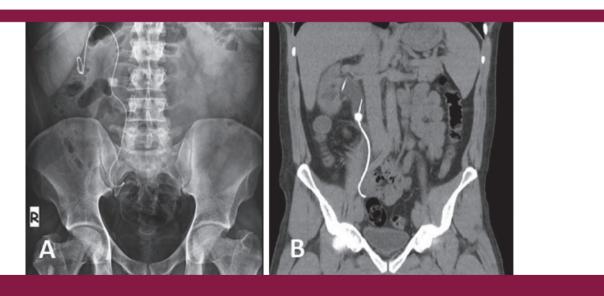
A). Control DUSG taken on the 1st postoperative day of the re-operated patient, B) Abdominal CT without contrast CT: Computed tomography, DUSG: Plain urinary system radiographs
